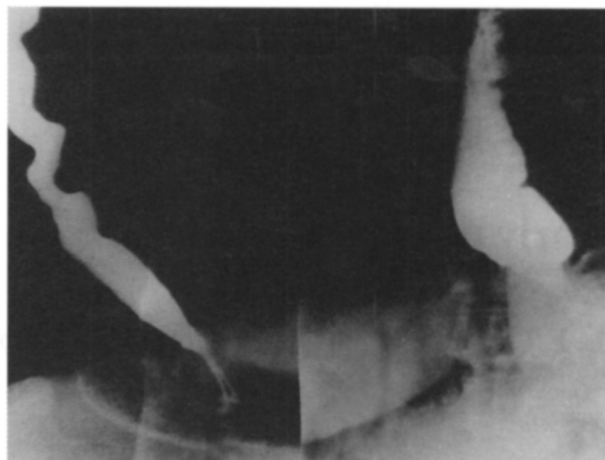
Barium swallow X-ray showing grade I and II achalasia.
